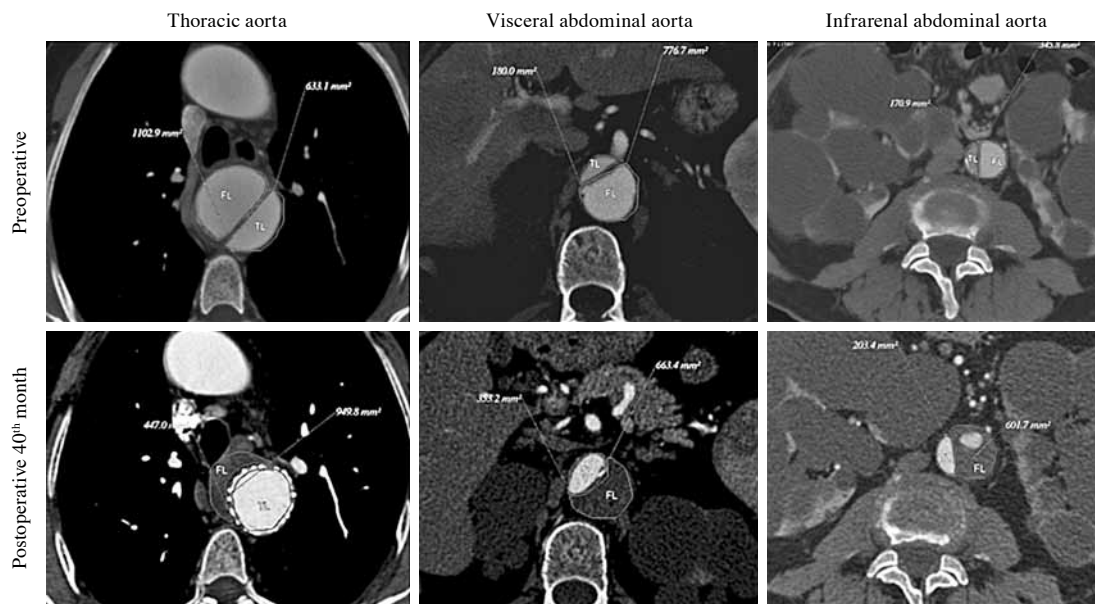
Computed tomography scans showing preoperative and postoperative volumes of true and false lumens.
